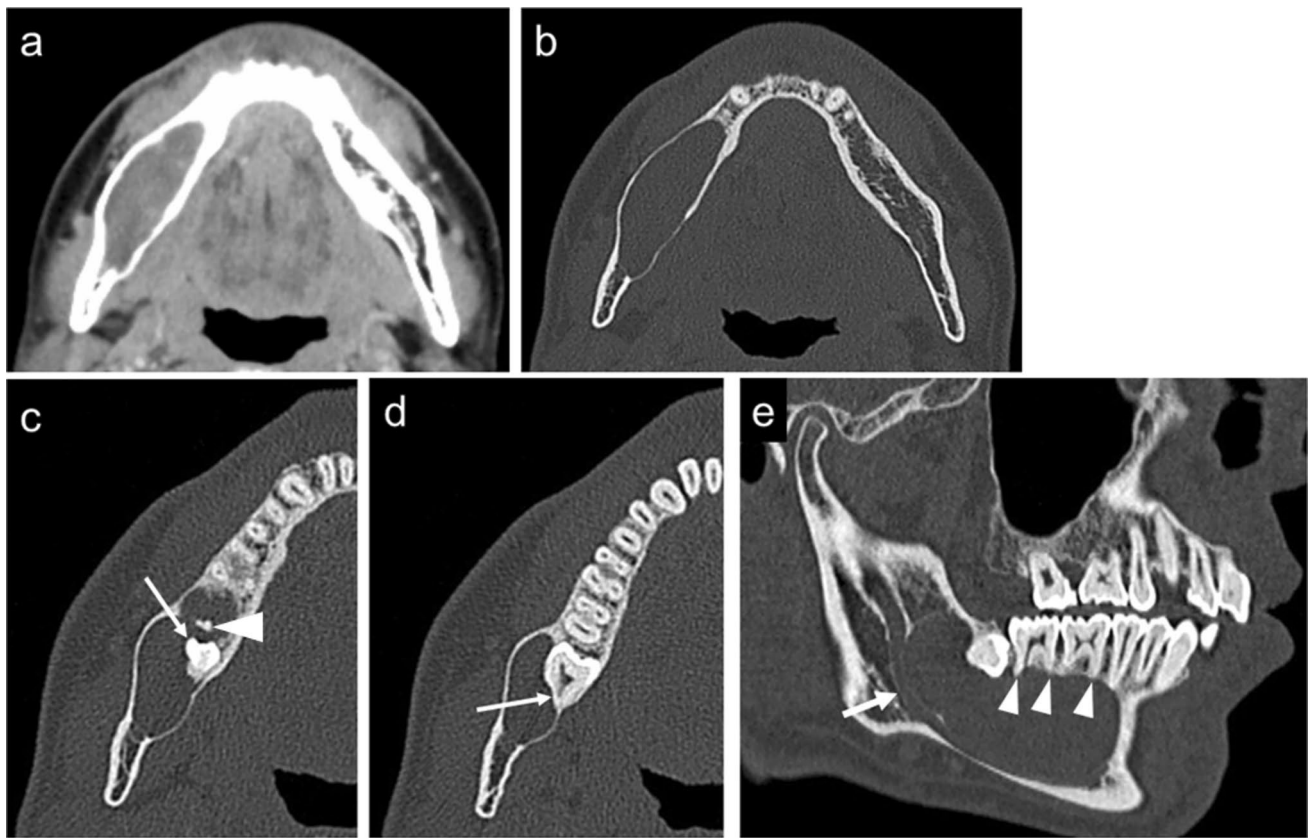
CT shows a slight expansile lesion extending from the second premolar region to the retromolar pad region. The internal density of the lesion is inhomogeneous and mostly lower attenuation than muscle on soft-tissue density window-setting (a). On axial bone window-setting images, the expansion of the mandible by the lesion is moderate to the buccal side and slight to the lingual side, with thinning of both sides of cortical bone (b). The part of the third molar
